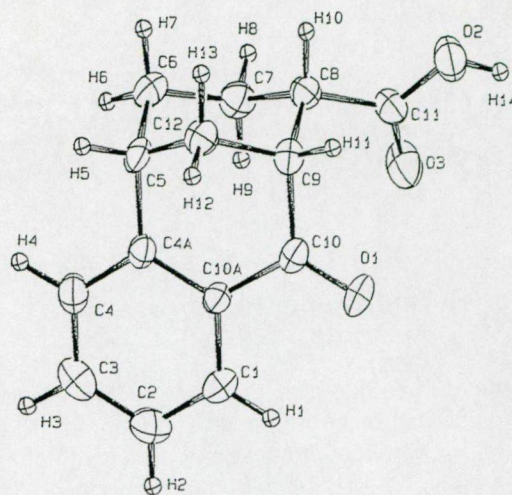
X-Ray structure of compound 4a.
